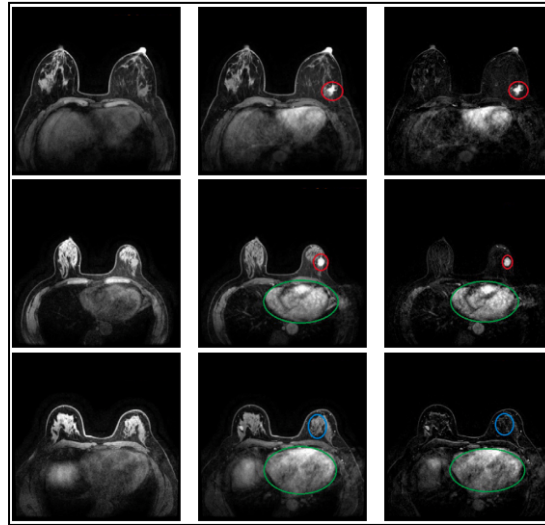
QIN DCE-MRI Image Dataset.
